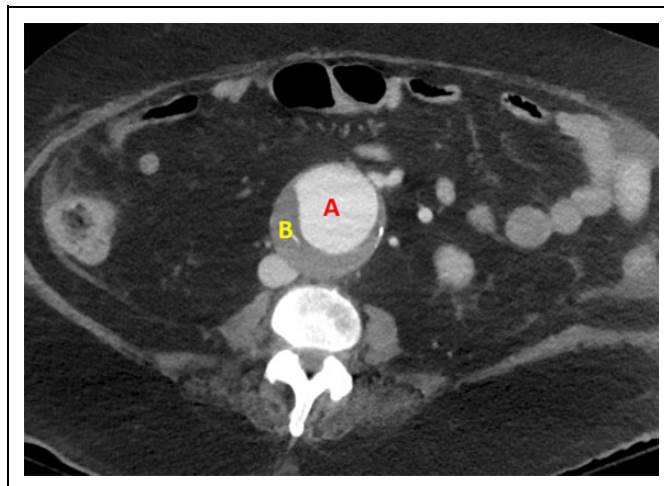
Abdominal CT image of the patient. A = Aortic lumen, highlighted by intravenous contrast material. B = Mural thrombus of aortic aneurysm. Computed tomography imaging was done with intravenous contrast material. Note the inferior vena cava (IVC) posterior and to the right of the mural thrombus. In a ruptured AAA, this would likely be obliterated. AAA indicates abdominal aortic aneurysm; CT computed tomography.
